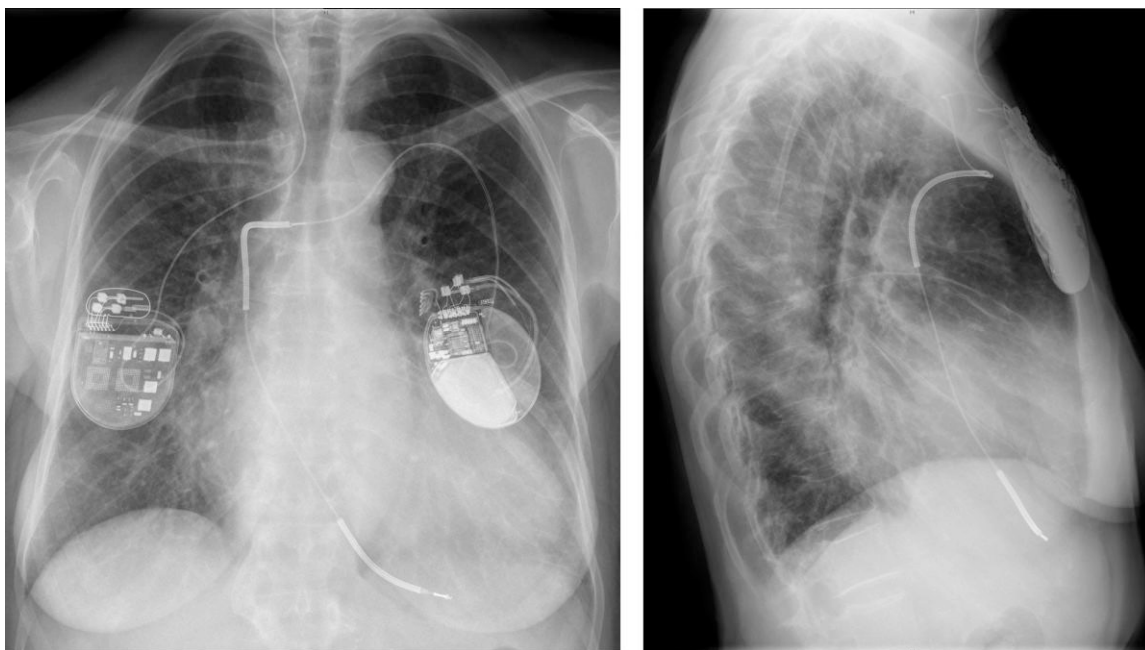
Chest X-ray showing a patient with a baroreflex activation therapy device (right pectoral device).
